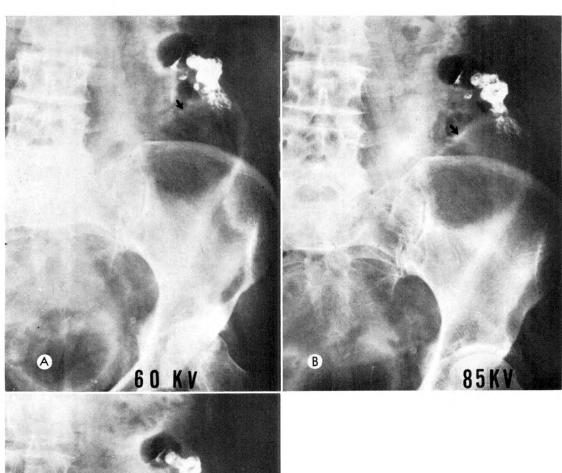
After a water enema, roentgenograms taken at (A) 60, (B) 85 and (C) 120 kv. confirm the submucous lipoma and demonstrate the superiority of low kilovoltage technique.
